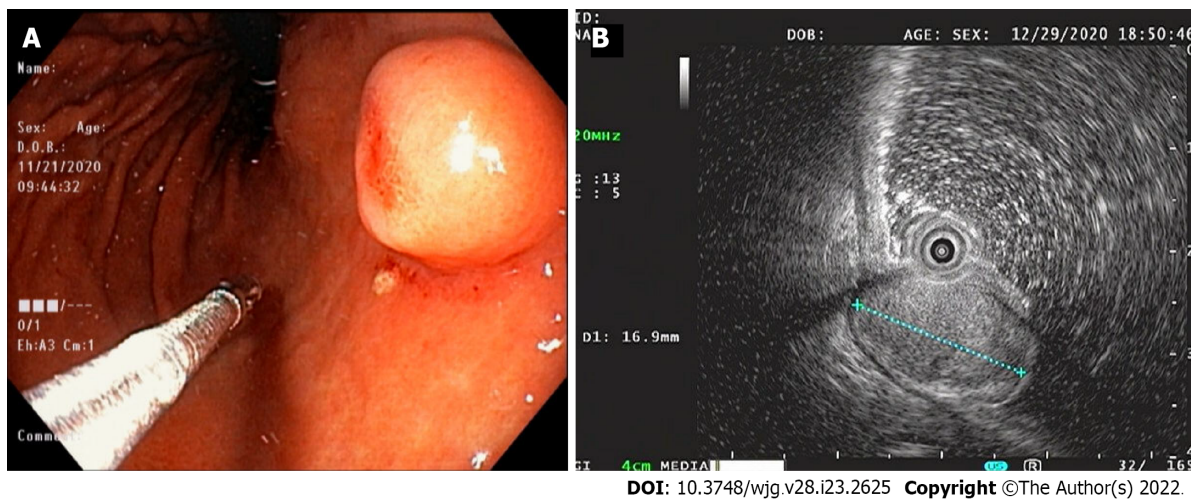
Endoscopy and endoscopic ultrasound images. A: Endoscopic image showing a 15-mm-sized, submucosal tumor-like, protruding lesion with focal mucosal erythema and depression of overlying mucosa; B: Endoscopic ultrasound image showing a well-circumscribed, slightly heterogeneous, 17 mm × 10 mm sized, isoechoic mass originating from the third sonographic layer.
